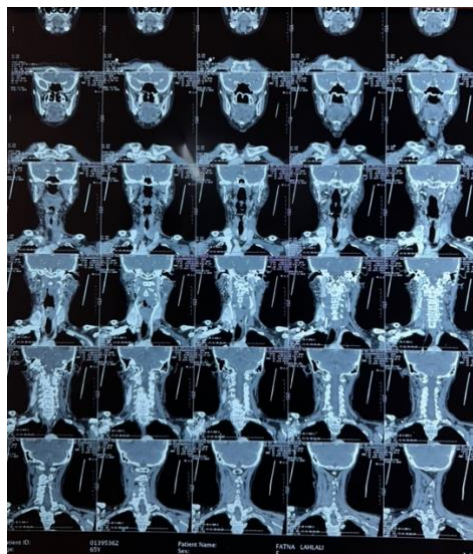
frontal view of the CT scan
